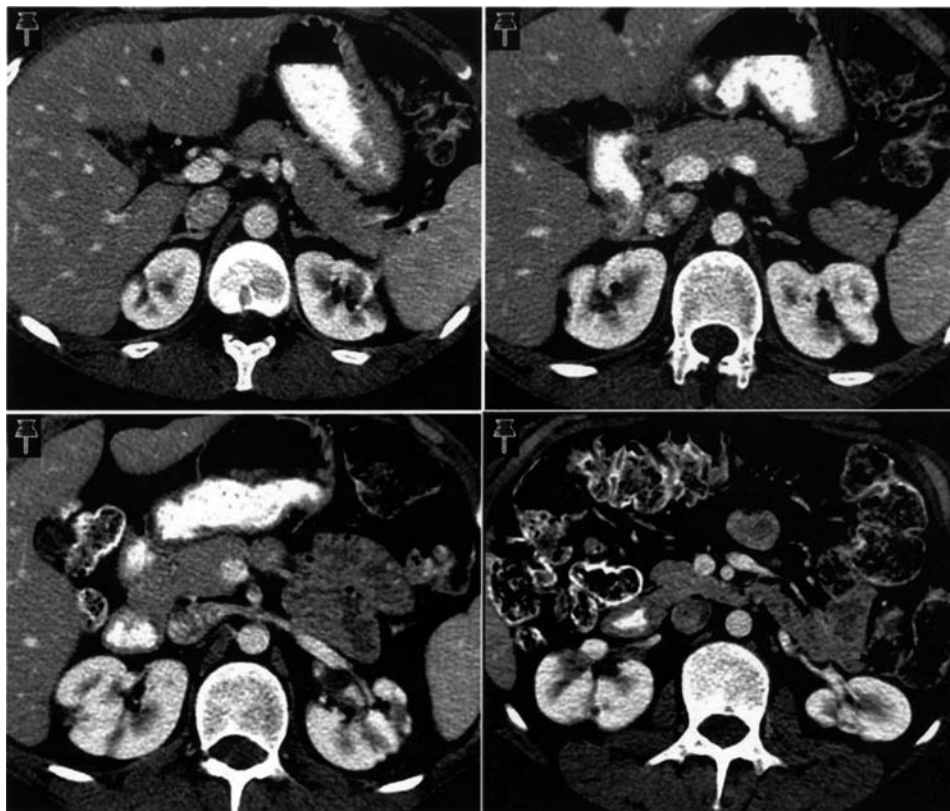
CT scan shows bilateral renal infarction.
